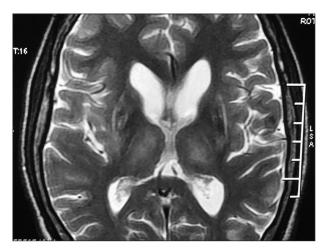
Bilateral thalamic hyperintensities seen on a T2-weighted image
